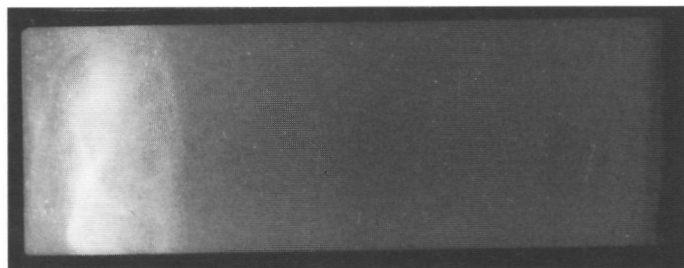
Radiograph of a centrifuged LVC cylinder. Bottom to the left.
